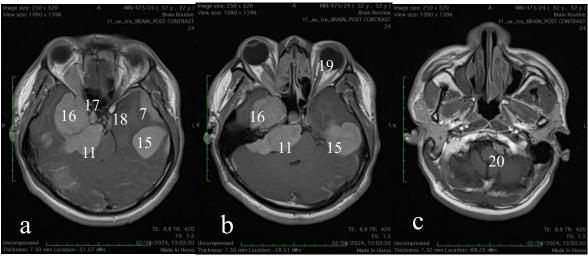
Axial T1W post gadolinium MRI of the brain showing dural based masses at (a:16-18) right sphenoid wing with extension into the orbit, right carvenous sinus and left carvenous sinus (b:19) right sphenoid wing extension to ethmoid sinuses (c:20) left foramen magnum
